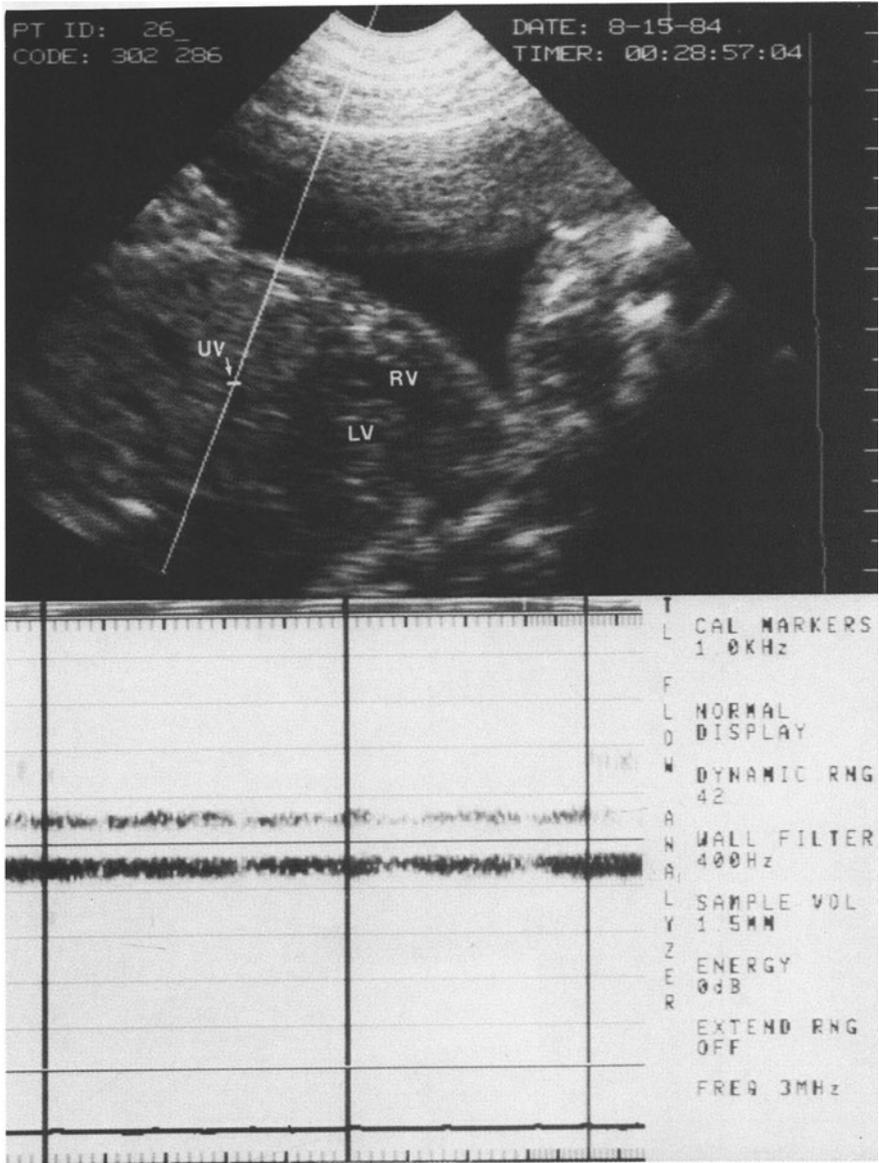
The top frame shows the Doppler sample volume within the umbilical vein (*UV*) of a 26-week-old fetus within the liver (abbreviations: *LV*, left ventricle; *RV*, right ventricle). The arrow shows the direction of blood flow. Below is the resulting, almost continuous flow below the baseline of the umbilical venous signal. Distal venous signals have characteristic smooth flow and have been used to calculate cardiac output.
